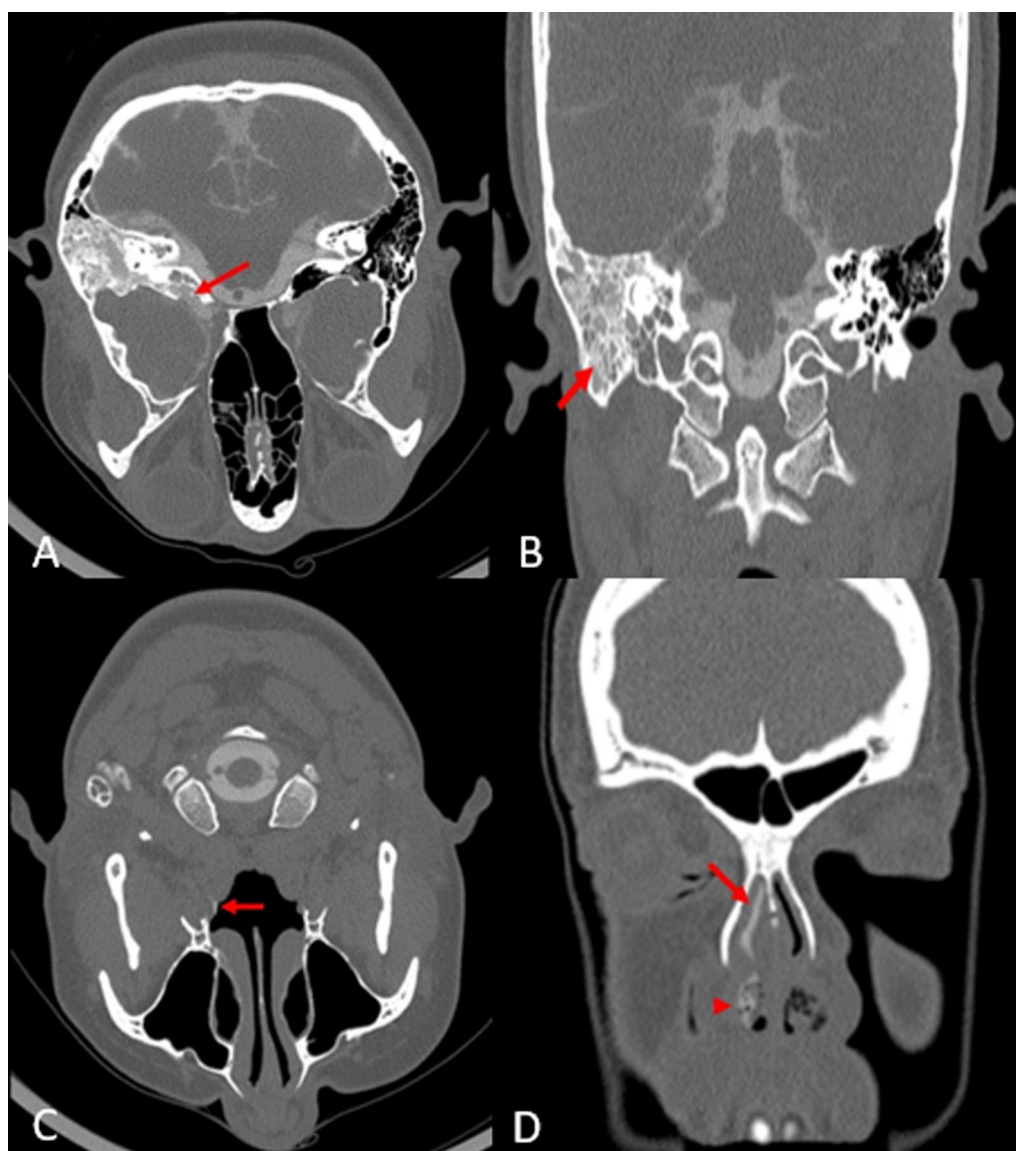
A CT cisternography performed in prone position depicting the scalloping along the antero-medial aspect of the right temporal bone (red arrow) with contrast leak through this into the adjacent hyper-pneumatized petrous bone. B CT cisternography coronal section demonstrating the increased density corresponding to the contrast leak into the right mastoid air cells (red arrow) and middle ear and C CT cisternography axial section demonstrating contrast leak at the nasopharyngeal opening of the right Eustachian tube (red arrow). D CT cisternography coronal section demonstrating the contrast leak into the right nares (red arrow) with the nasal pledgets showing contrast soakage (red arrowhead)
